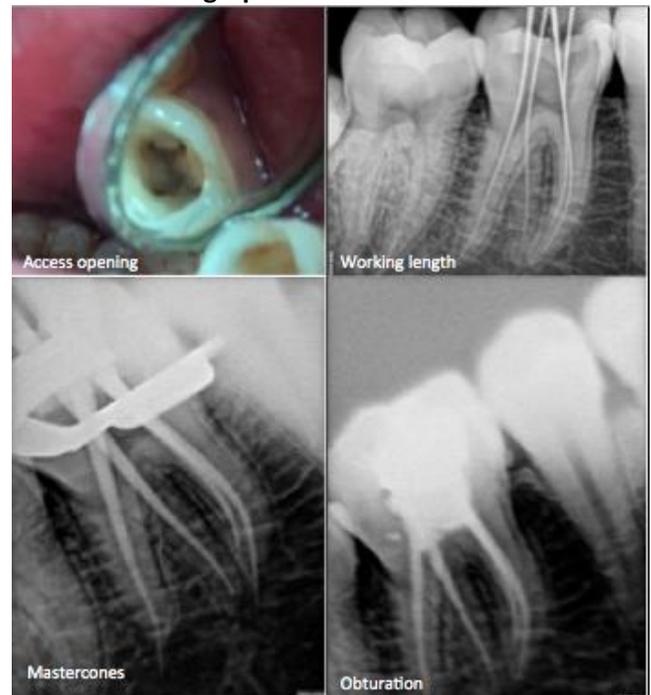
Case 2. Upper left - Access opening, Upper right - Working length radiograph, Lower left - Mastercone radiograph, Lower right - Post-obturation radiograph
